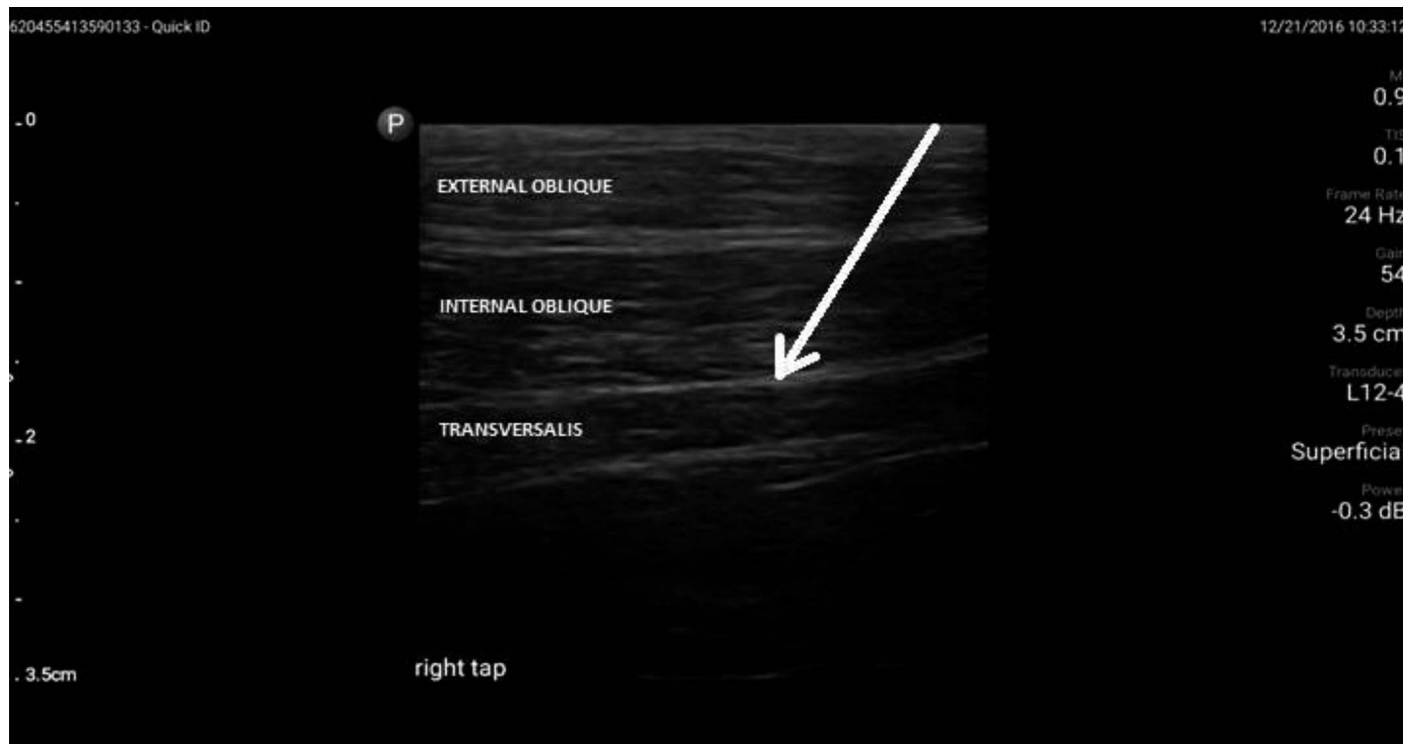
Ultrasound image of the needle insertion in TAP block.
